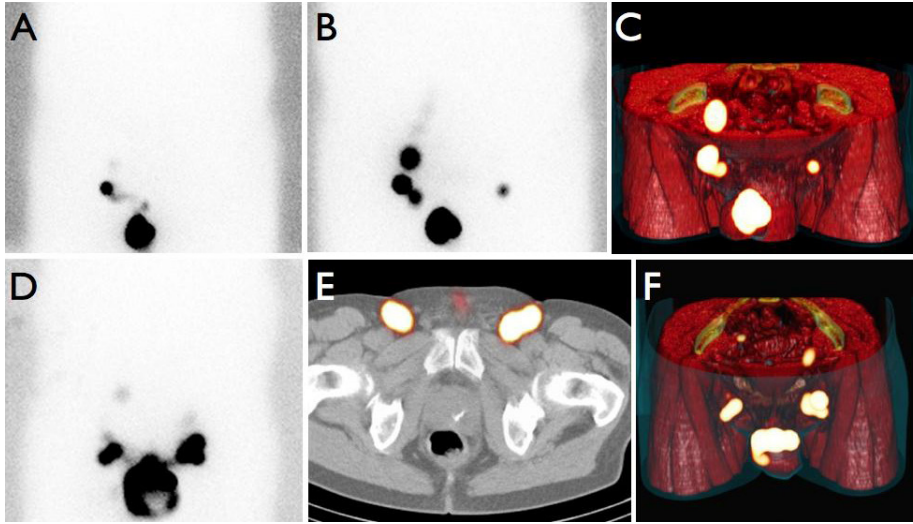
Lymphoscintigraphy showing early drainage to the right groin (A) and delayed SLN visualization in the left groin (B). SPECT/CT image displayed using volume rendering (C) shows more accurately the anatomical localization, thus differentiating inguinal from iliac nodes. In another patient, bilateral drainage is seen in the planar image (D), while the SPECT/CT image shows a cluster of SLNs in the left groin and two SLNs in the right groin (E, F).
